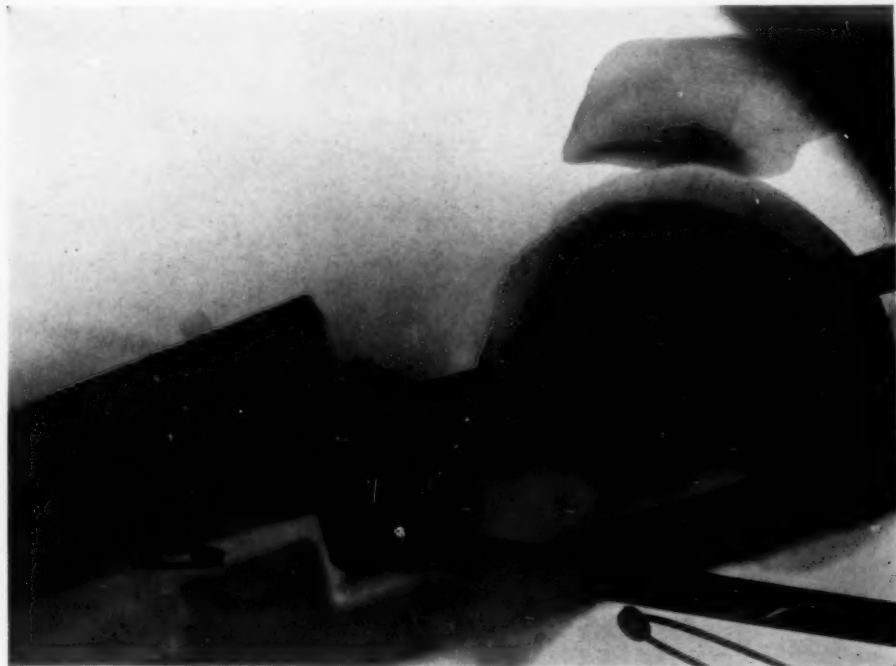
Thirty pounds pull through Steinmann pin in tibia; knee-joint about 30 degrees flexed. Note marked backward tilting of lower fragment. X-ray after third day.
